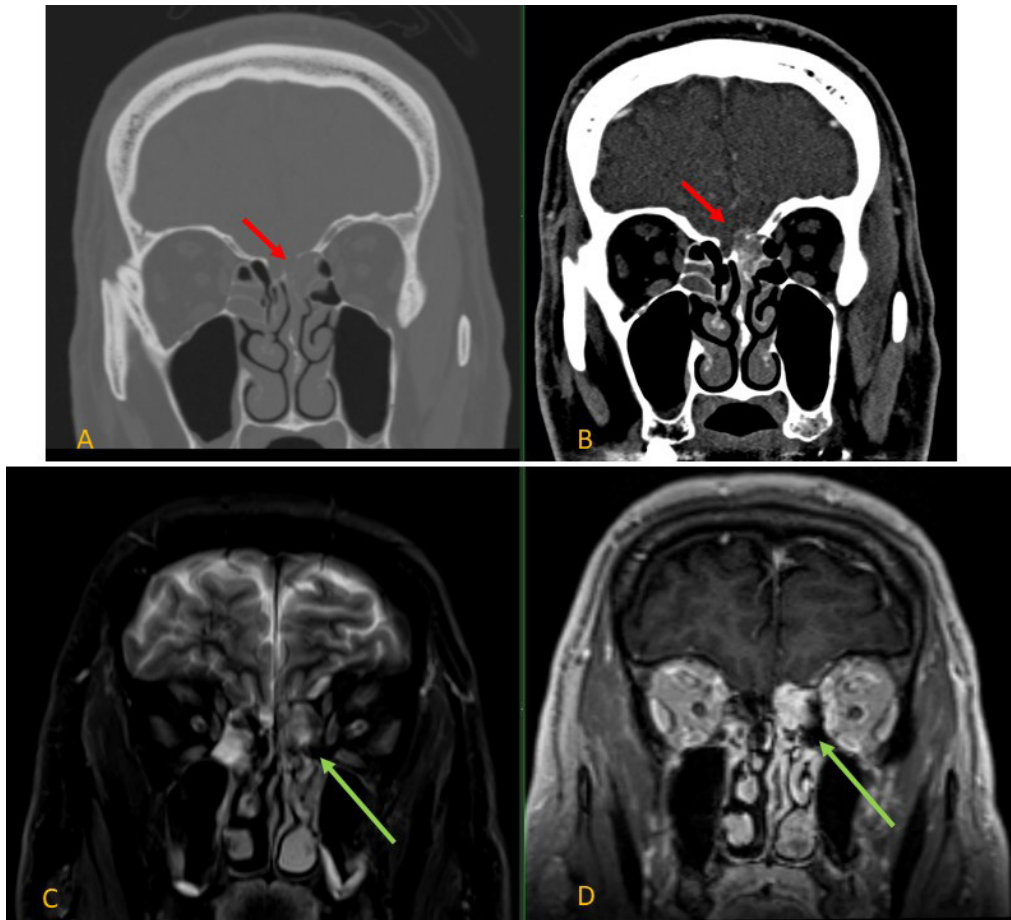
Coronal CT in bone window (A) demonstrates the left ethmoid mass eroding the cribriform plate and left lateral lamella. Coronal CTA in soft tissue window (B) shows the mass displaying arterial enhancement. Coronal T2 MRI (C) demonstrates isointensity of the left ethmoid mass as compared to the brain parenchyma. Coronal T1 post contrast MRI (D) displays homogenous enhancement of the mass.
